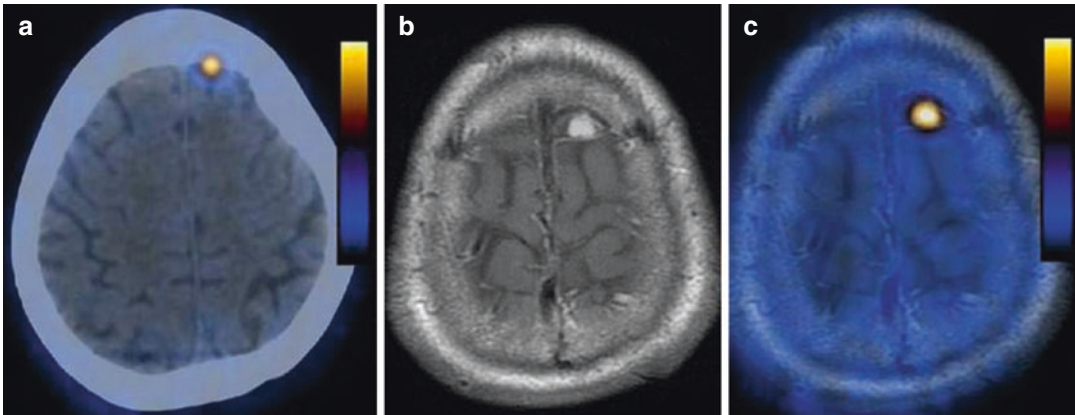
A patient was examined by means of whole body ^{18}F -FMC PET/CT for restaging prostate cancer. A focal area of uptake was detected in left frontal region, evident in axial PET/CT view (a). The lesion was diagnosed
